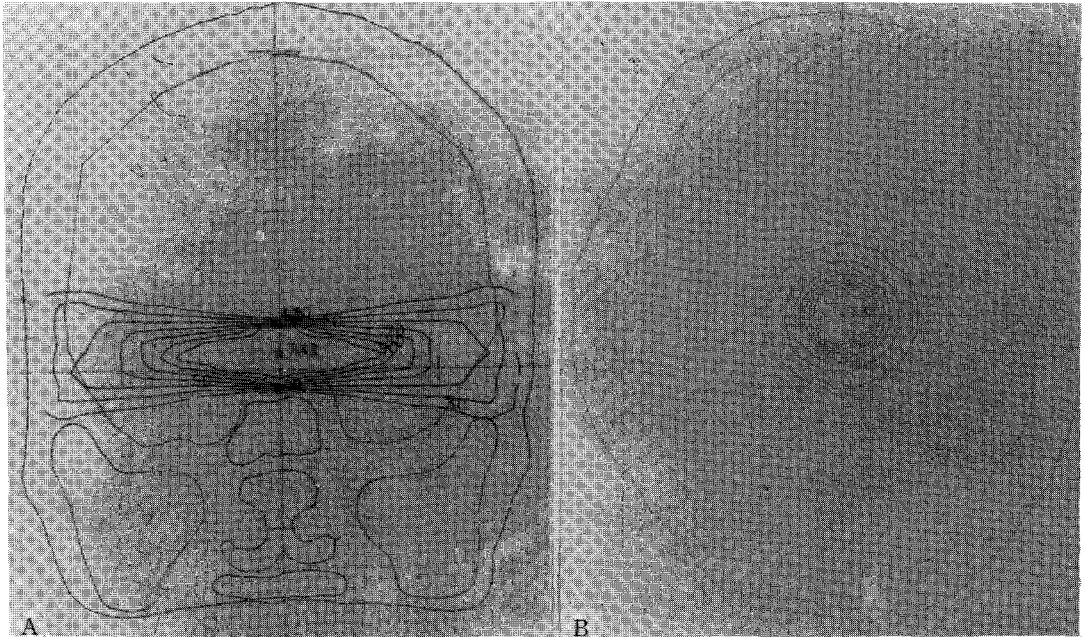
Dose distribution on the coronal and transverse planes for  $2 \times 2 \text{ cm}^2$  field at the isocenter, for a 6 MV X-ray beam. A) coronal plane, B) transverse plane.
